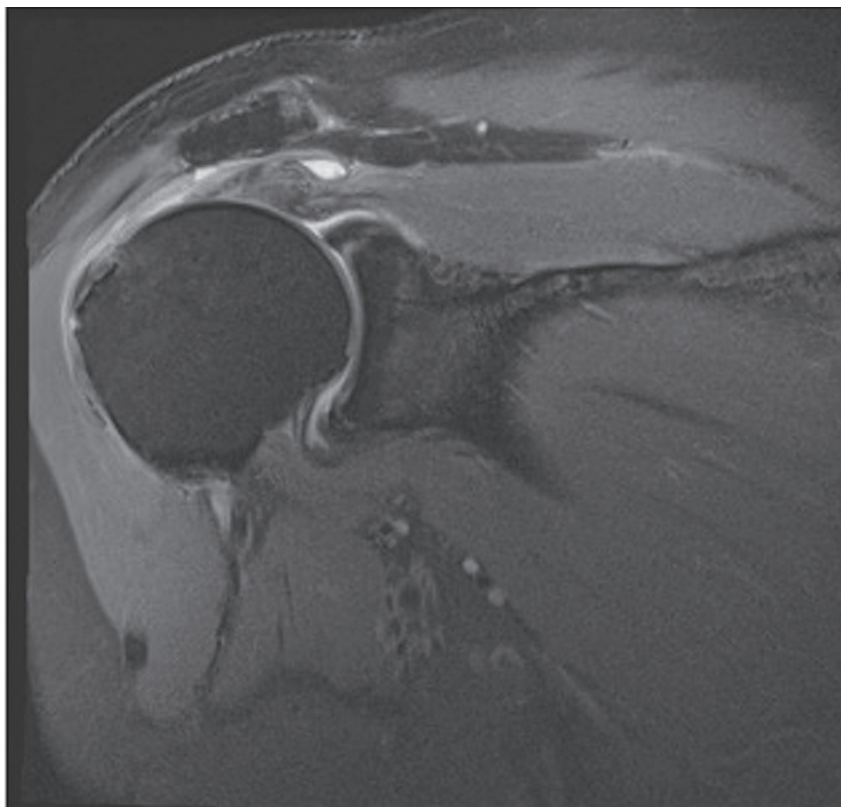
Coronal T2-weighted fat suppressed imaging shows a full thickness tear of the supraspinatus tendon.
